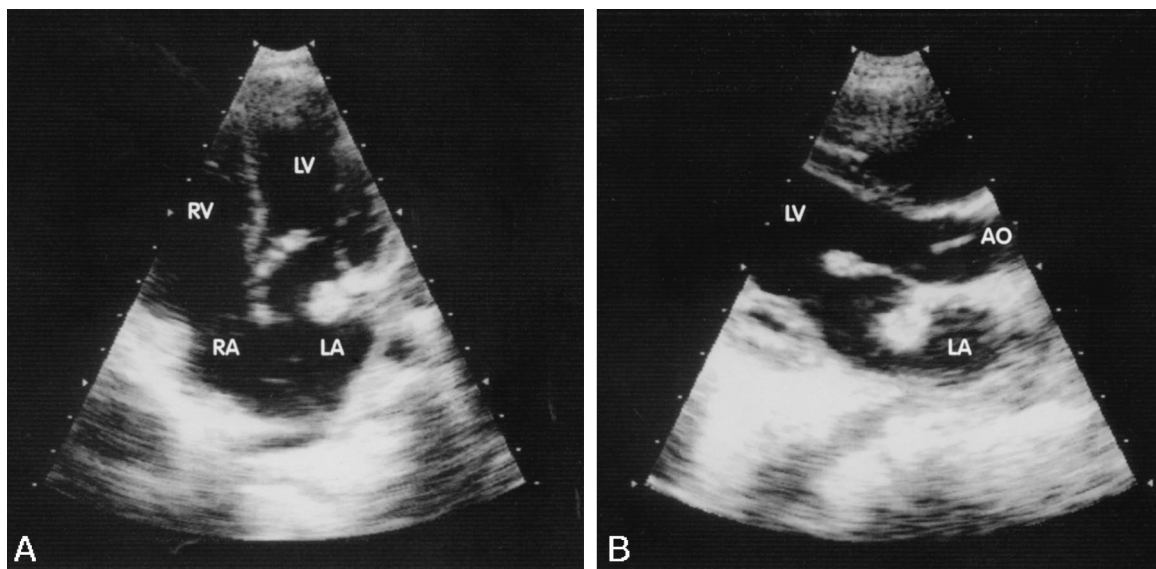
Echocardiograms in two views (A and B) showing the intussusception of the left atrial appendage. AO, Aorta; LA, left atrium; LV, left ventricle; RA, right atrium; RV, right ventricle.
